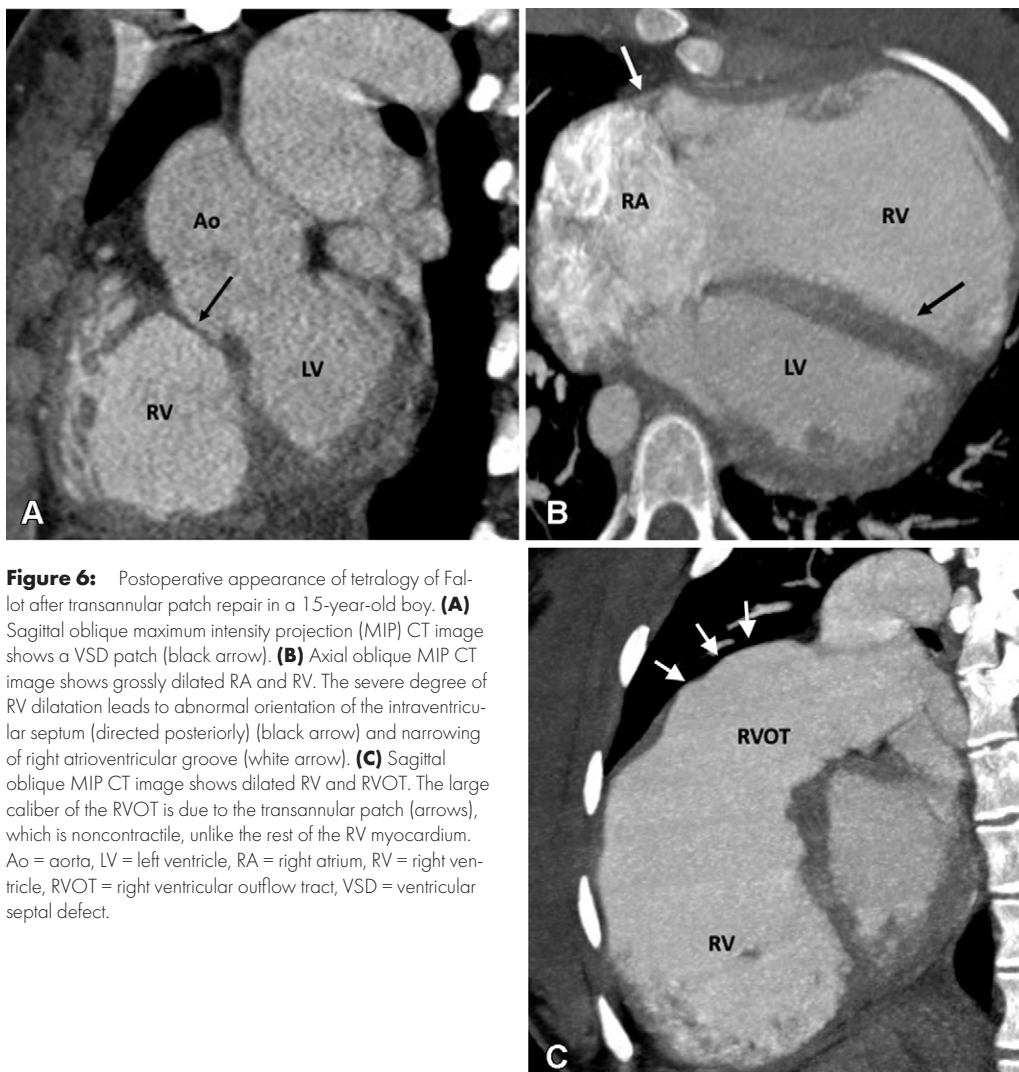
Postoperative appearance of tetralogy of Fallot after transannular patch repair in a 15-year-old boy. (A) Sagittal oblique maximum intensity projection (MIP) CT image shows a VSD patch (black arrow). (B) Axial oblique MIP CT image shows grossly dilated RA and RV. The severe degree of RV dilatation leads to abnormal orientation of the intraventricular septum (directed posteriorly) (black arrow) and narrowing of right atrioventricular groove (white arrow). (C) Sagittal oblique MIP CT image shows dilated RV and RVOT. The large caliber of the RVOT is due to the transannular patch (arrows), which is noncontractile, unlike the rest of the RV myocardium. Ao = aorta, LV = left ventricle, RA = right atrium, RV = right ventricle, RVOT = right ventricular outflow tract, VSD = ventricular septal defect.
